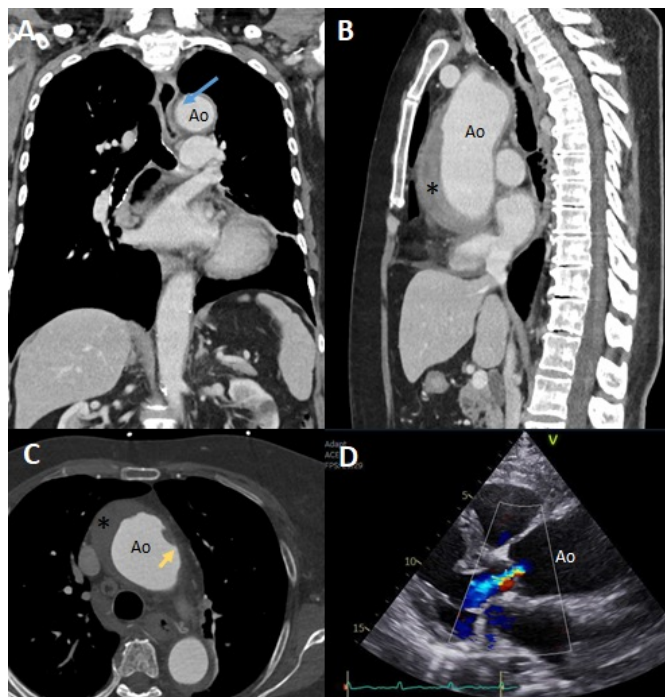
(A) Coronal computed tomography (CT) image showing extrinsic esophageal compression (blue arrow) by the aorta (B) in sagittal CT the ascending aorta shows a crescentic thickening (asterisk) of the aortic wall resembling an intramural hematoma. (C) Axial cardiac CT image at the level of distal ascending aorta, a discrete disruption of the intima is seen (yellow arrow) (D) echocardiogram paraesophageal long axis demonstrates aortic root dilatation with consequent, central, mild to moderate aortic insufficiency
